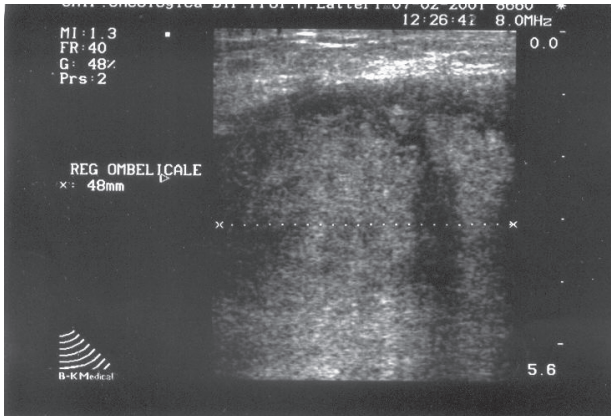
Ultrasound examination demonstrated a solid iperechogenic mass into subcutaneous tissue.
